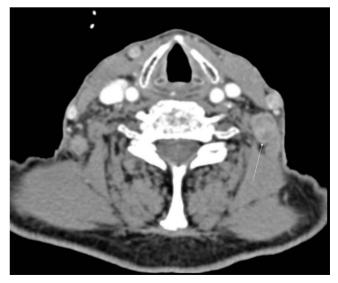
Axial contrast-enhanced CT showing tuberculous partly necrotic nodes in the left lower neck (white arrow).
